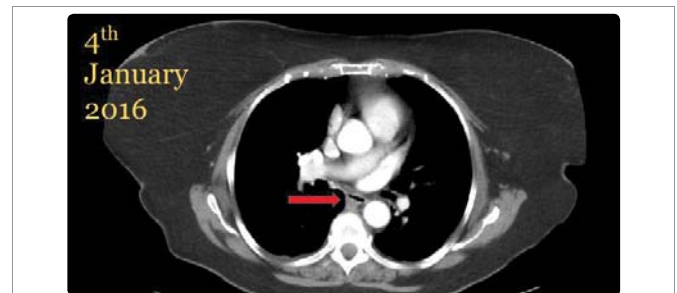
CT scan from 1 year ago showing normal appearing, collapsed esophagus (arrow).
